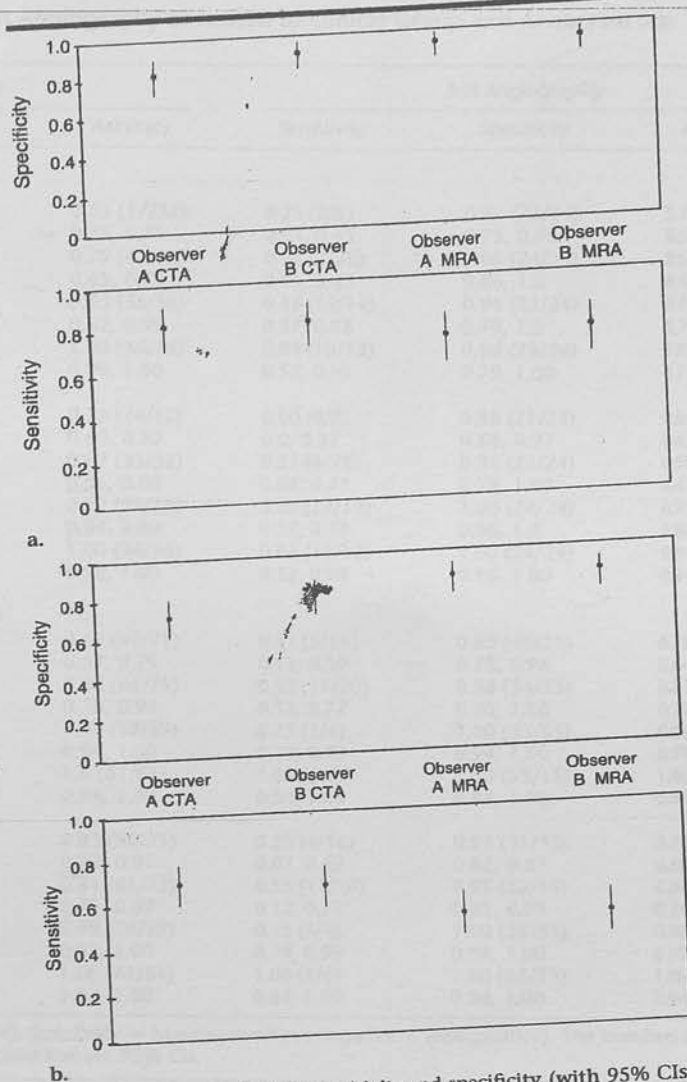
Forrest plots of sensitivity and specificity (with 95% CIs) for CT angiography (CTA) and MR angiography (MRA) (a) per patient and (b) per aneurysm for both observers.
